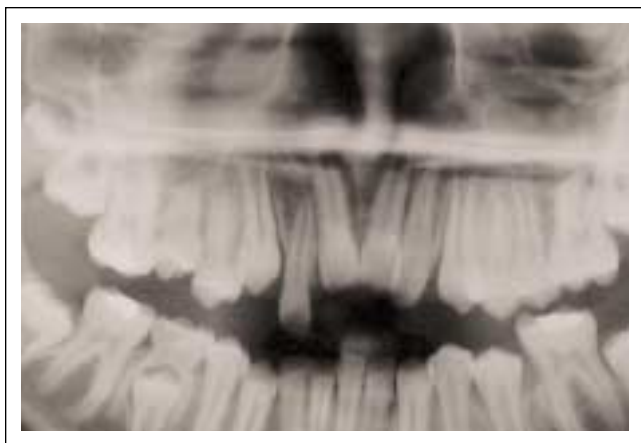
Panoramic radiograph confirming presence of intruded maxillary central incisors.
